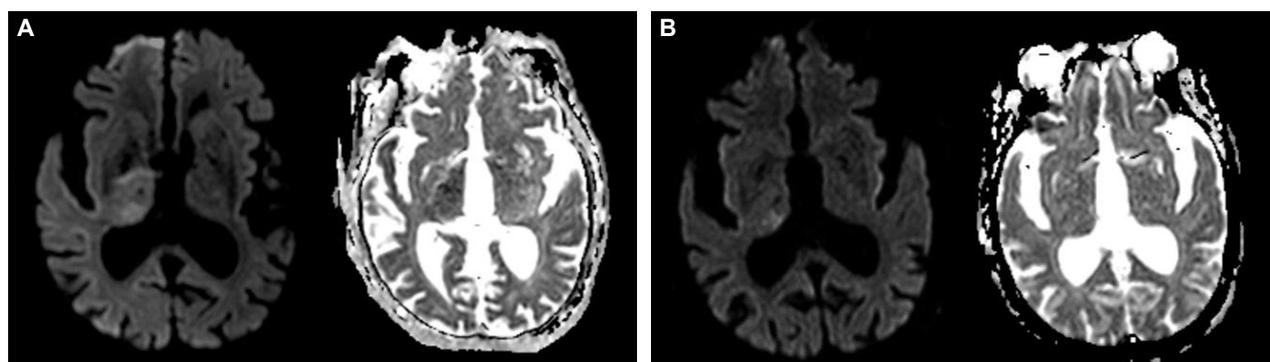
Diffusion-weighted MR images (DWI) and apparent diffusion coefficient (ADC). (A) Initial DWI showed high signal intensity in the entire right thalamus, in which the value of ADC was reduced. (B) High signal intensity was well-localized on the right pulvinar area in the follow-up DWI.
